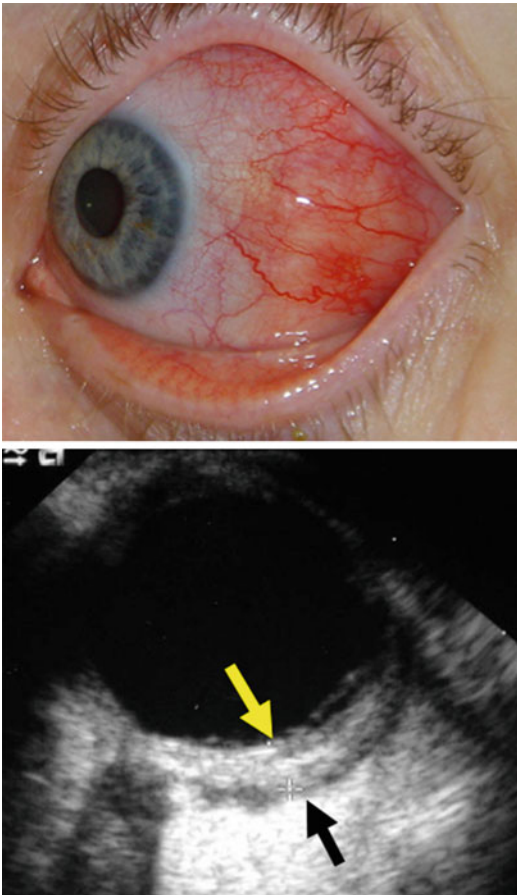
Scleritis, with ultrasound identifying gross thickening of sclera (delineated by the two arrows) and oedema within the optic nerve sheath
